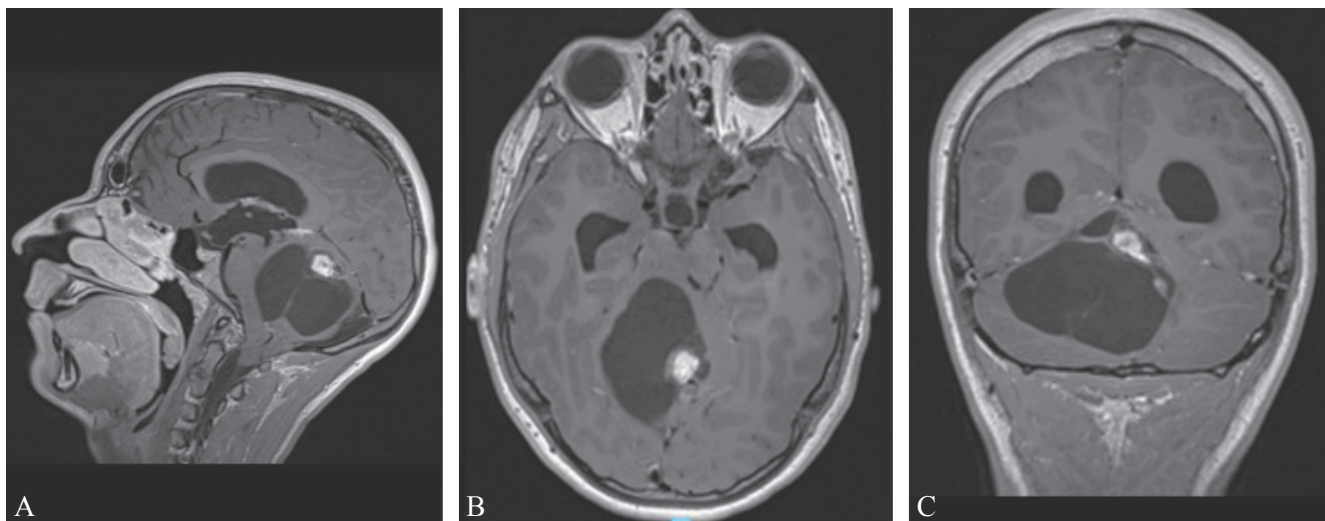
Sagittal (A), axial (B), coronal (C) MRI demonstrated a solid-cystic vermian lesion with a right cerebellar hemispheric extension suspicious for pilocytic astrocytoma.
